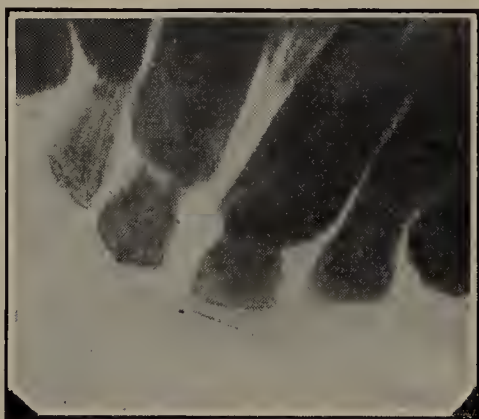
Patient of Dr. Price. Radiograph of the superior front teeth of a boy eight years of age. His mother and grandmother had lacked the permanent laterals, and it was feared he would also, and steps were being taken to prevent the first being shed, when the radiograph was taken, which shows clearly that the boy will get his permanent laterals.
